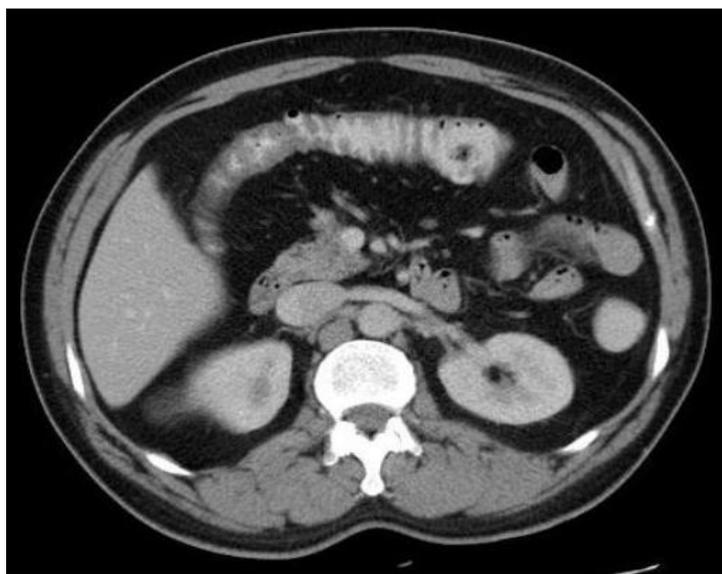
CT- Carcinoma Transverse colon (Homogenous enhancement)
